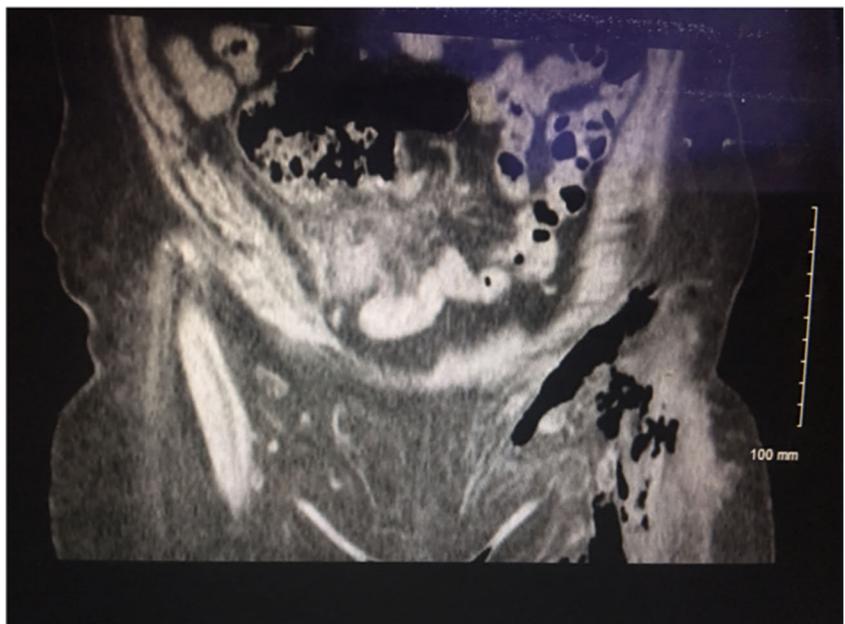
Axial image of CT pelvis without IV contrast demonstrating an inflammatory mass in the right lower quadrant of the abdomen
